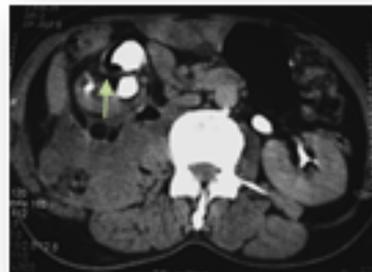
USG image showing multiple air specks in the right renal pelvicalyceal system producing "dirty" shadowing with a psoas abscess noted posterior to the kidney. Fig 31: Pyelographic phase image of a CT urography study showing the right kidney displaced anteriorly by a large abscess in the posterior paranephric space and right psoas. Air is noted along with excreted contrast (arrow) in the pelvicalyceal system of the right kidney and in perinephric space, suggestive of extensive infection. This was a case of Emphysematous Pyelonephritis in a diabetic patient.
